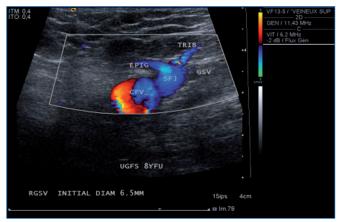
Eight year follow-up after ultrasound-guided foam sclerotherapy. GSV, great saphenous vein; EPIG, epigastric vein; TRIB, tributary; CFV, common femoral vein; SFJ, saphenofemoral junction. (Courtesy C. Hamel-Denos MD)
